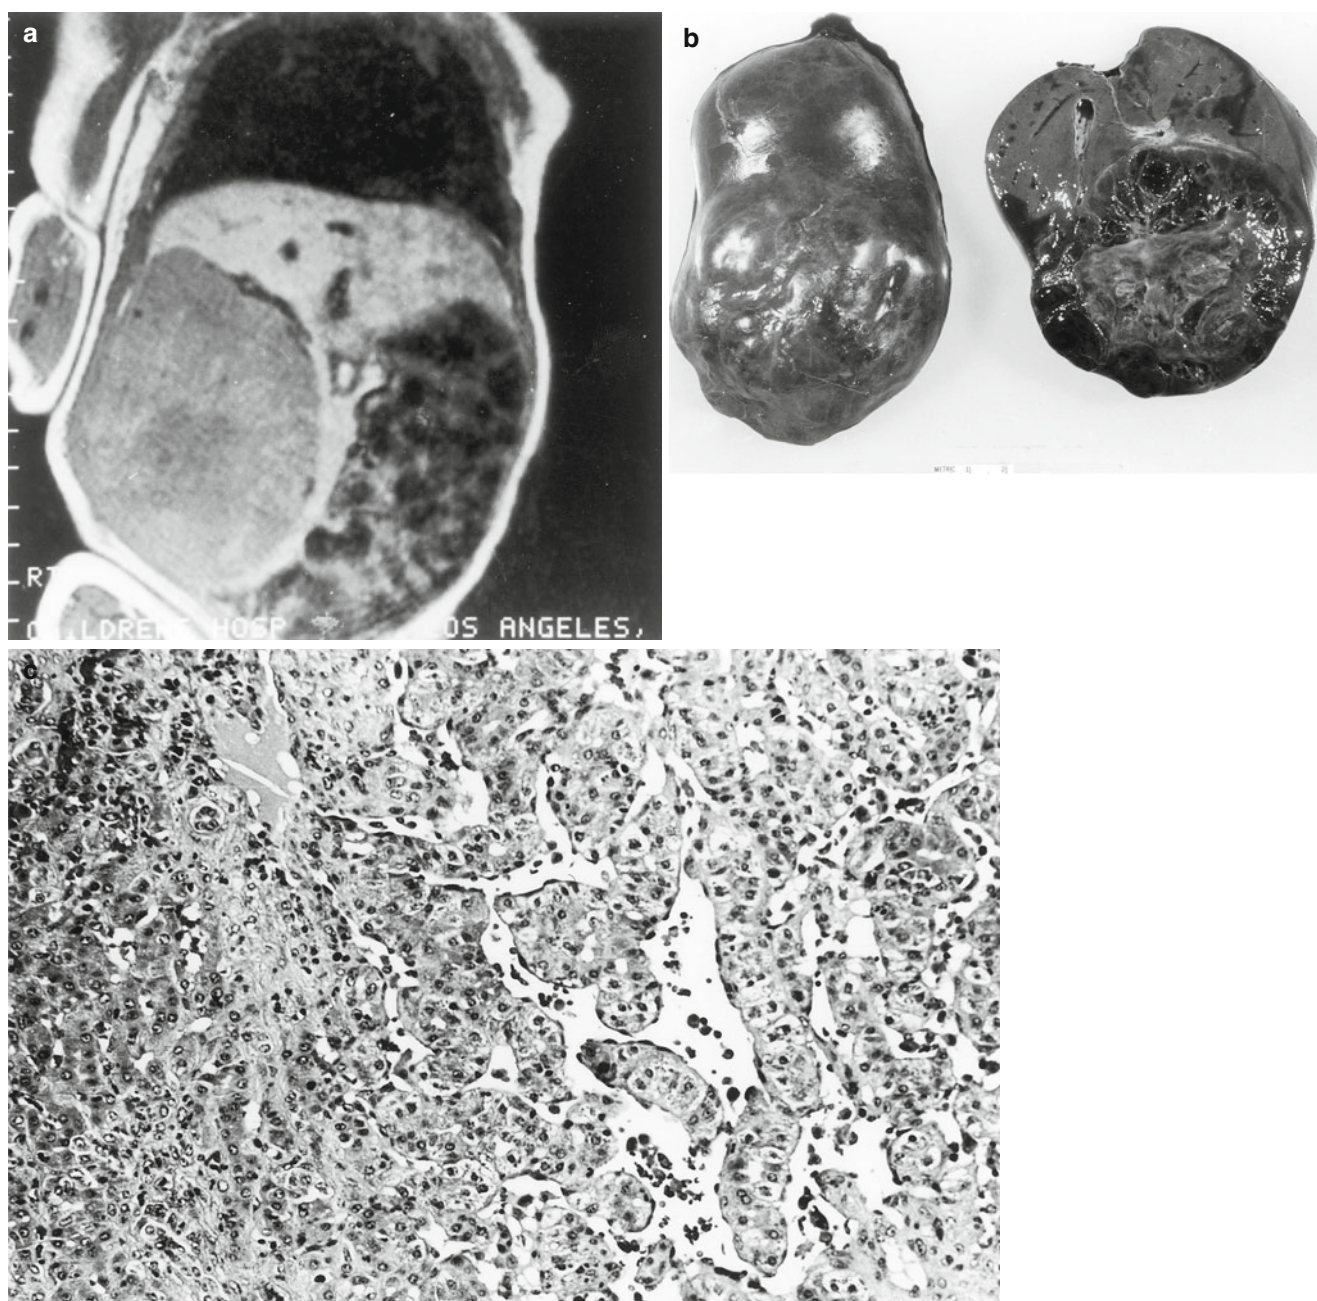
Hemangioma of the liver. Six-day-old male with an abdominal mass and the Kasabach-Merritt syndrome. (a) MRI scan demonstrating a large mass of variable density situated in the right lobe of the liver with features consistent with a hemangioma.
